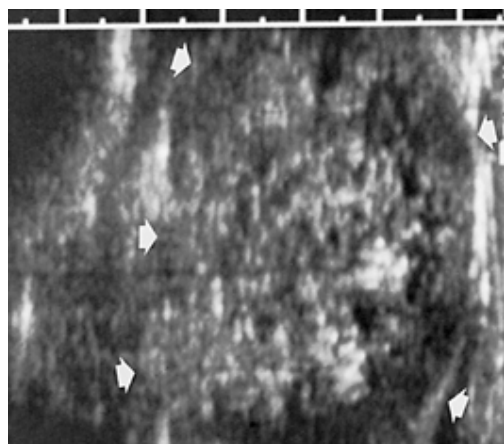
Autosomal-recessive polycystic kidney disease in newborn. Renal ultrasonography reveals marked renal enlargement with heterogeneous pattern and myriad fine cysts. Arrows denote renal margin.
